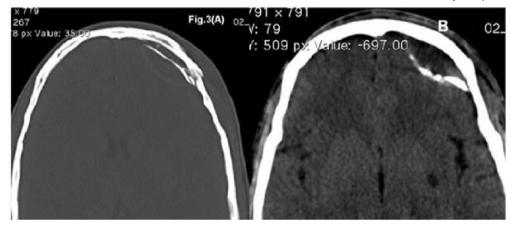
(A & B) 26 years old male Axial Non contrast CT scan shows depressed fracture of frontal bone on left with resolving EDH and a thin hyperdense inner margin.
